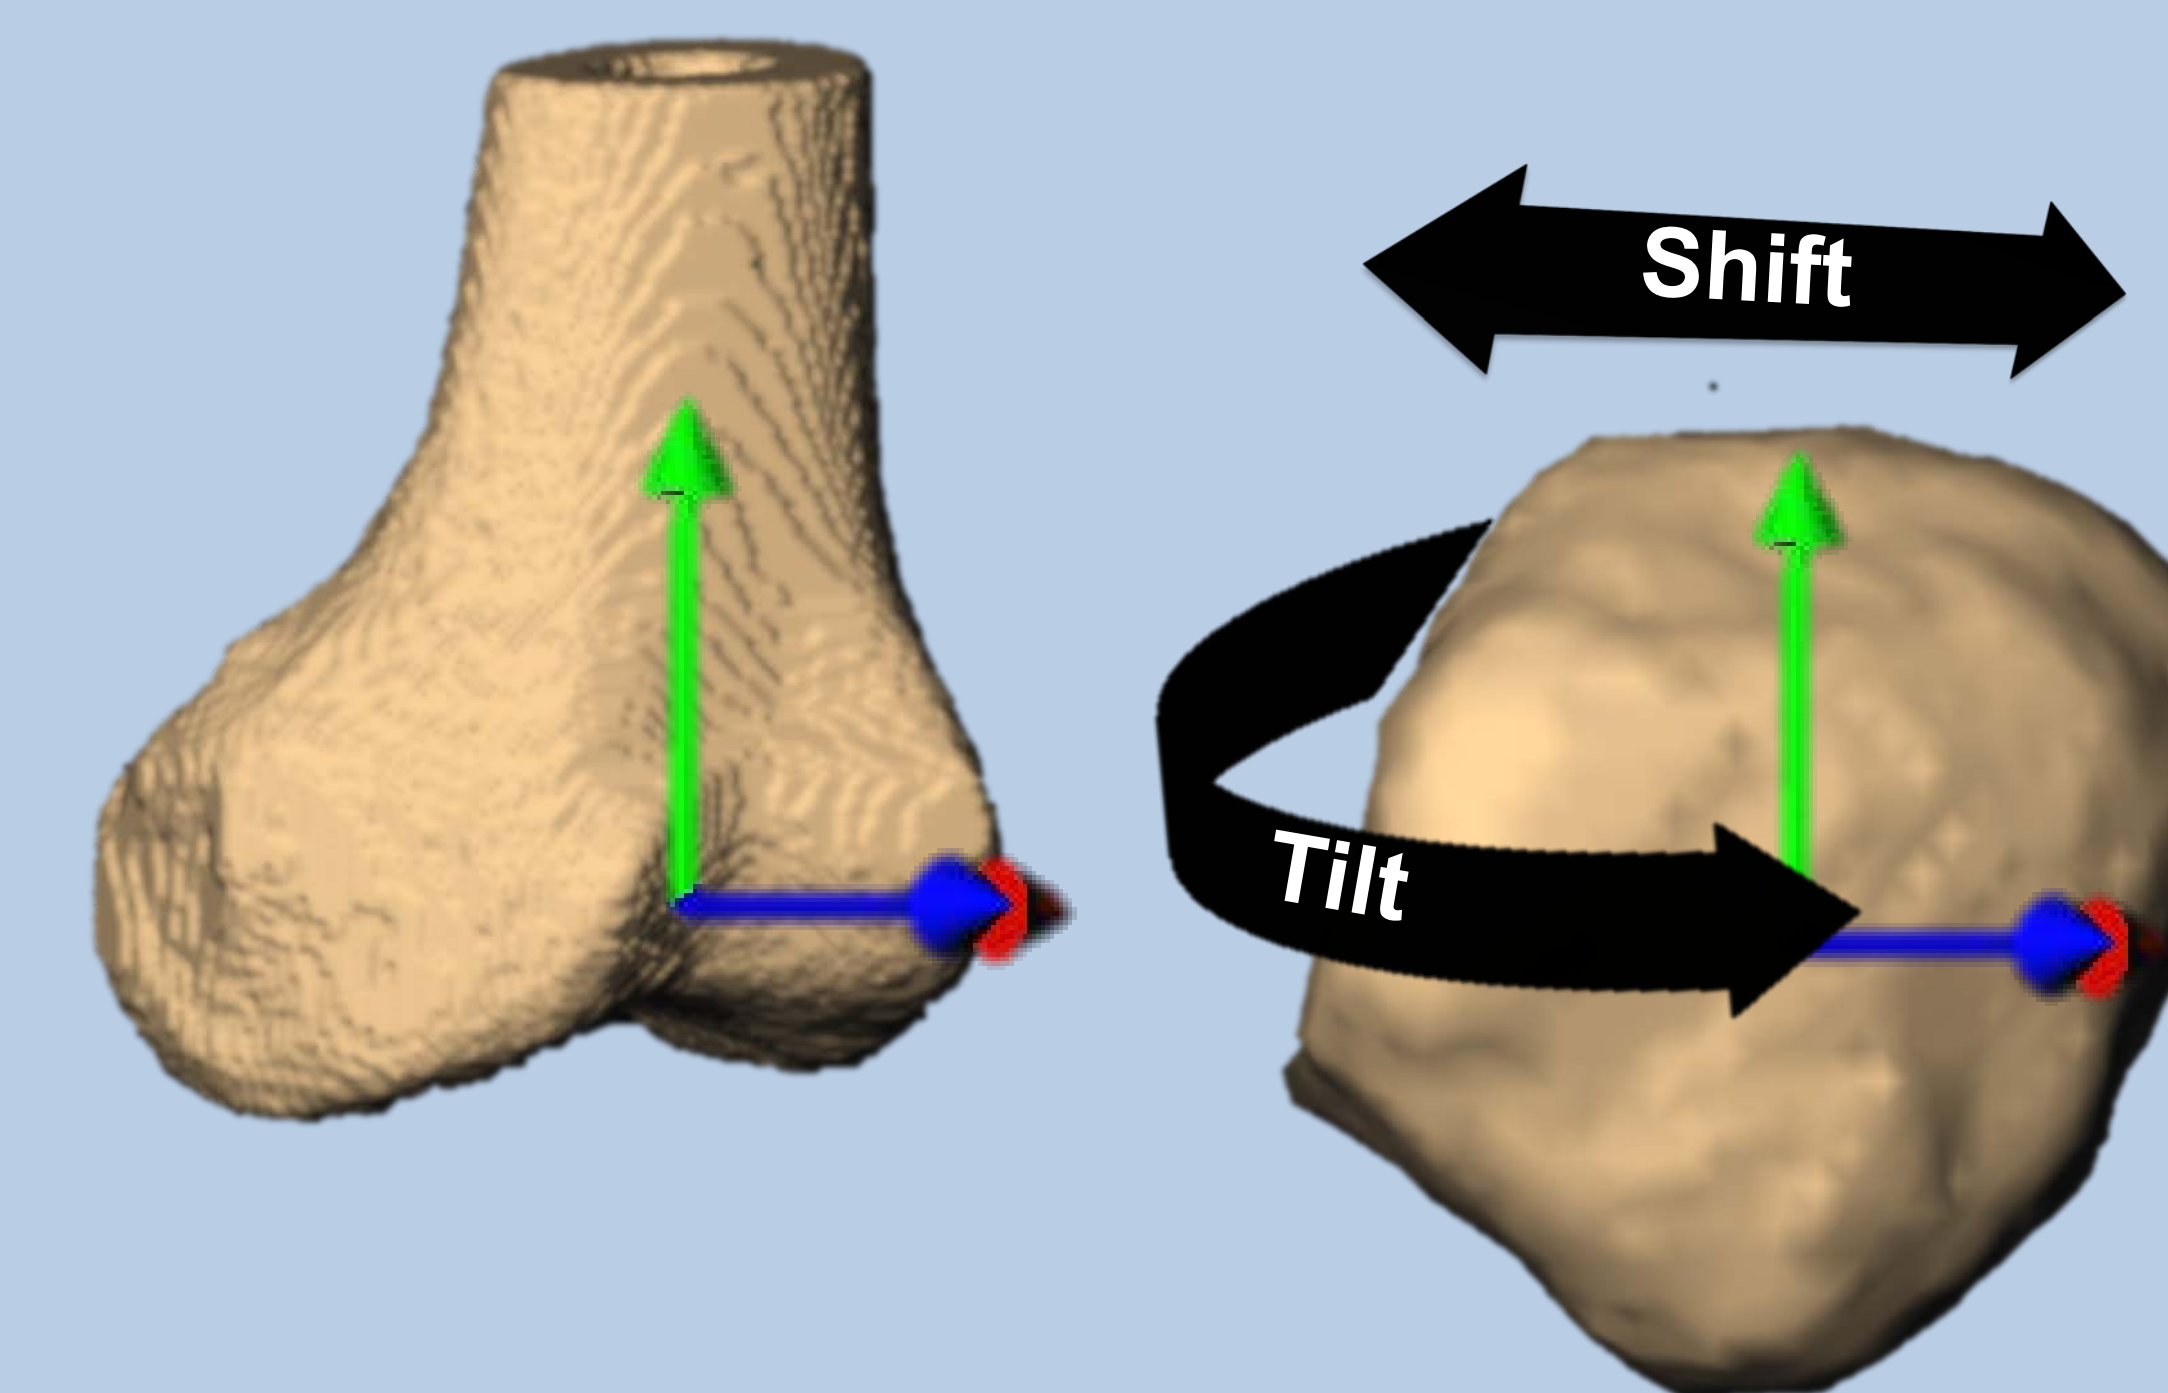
Subject specific bone models created from CT scan showing the anatomic axis: X (red), Y (green), Z (blue), Patellar shift (medial-lateral translation) and tilt (defined as rotation about the patella's long axis)⁴ was calculated using the patellar anatomic axis relative to the femur.
